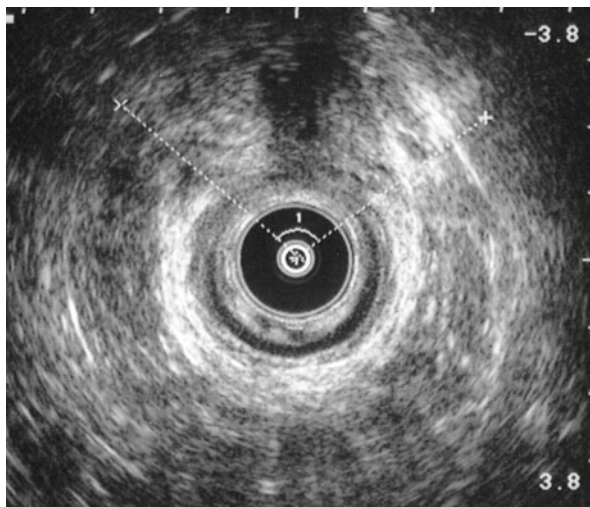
Endoanal ultrasound with anterior sphincter defect (internal and external)
